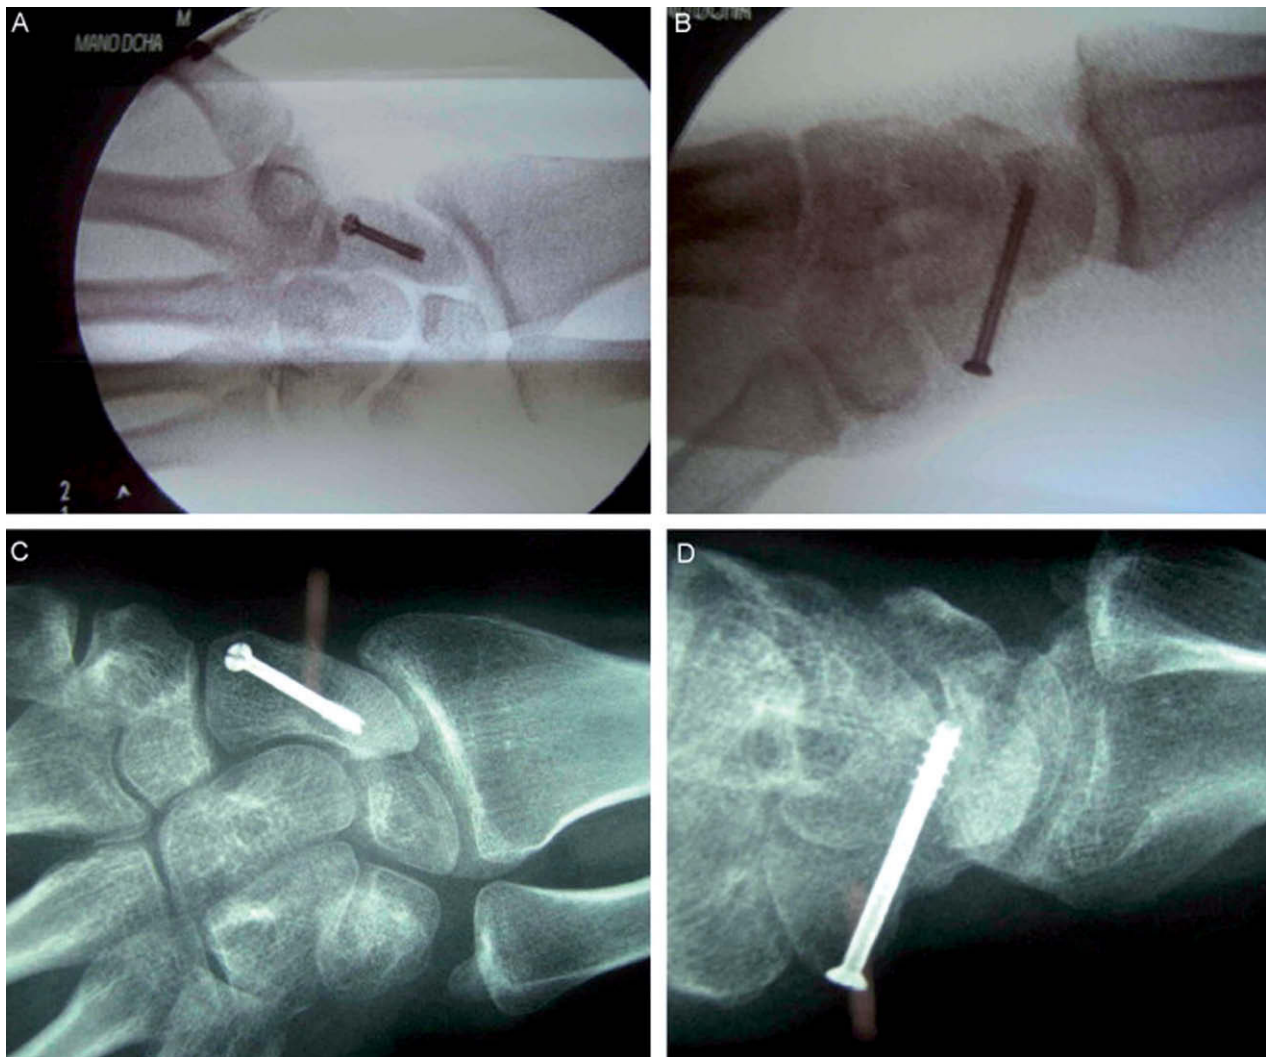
Fracture healing. Standard case. A) Intraoperative control. B) Intraoperative control. C) X-ray view at one year showing healing of the fracture. D) X-ray view at one year showing healing of the fracture.
